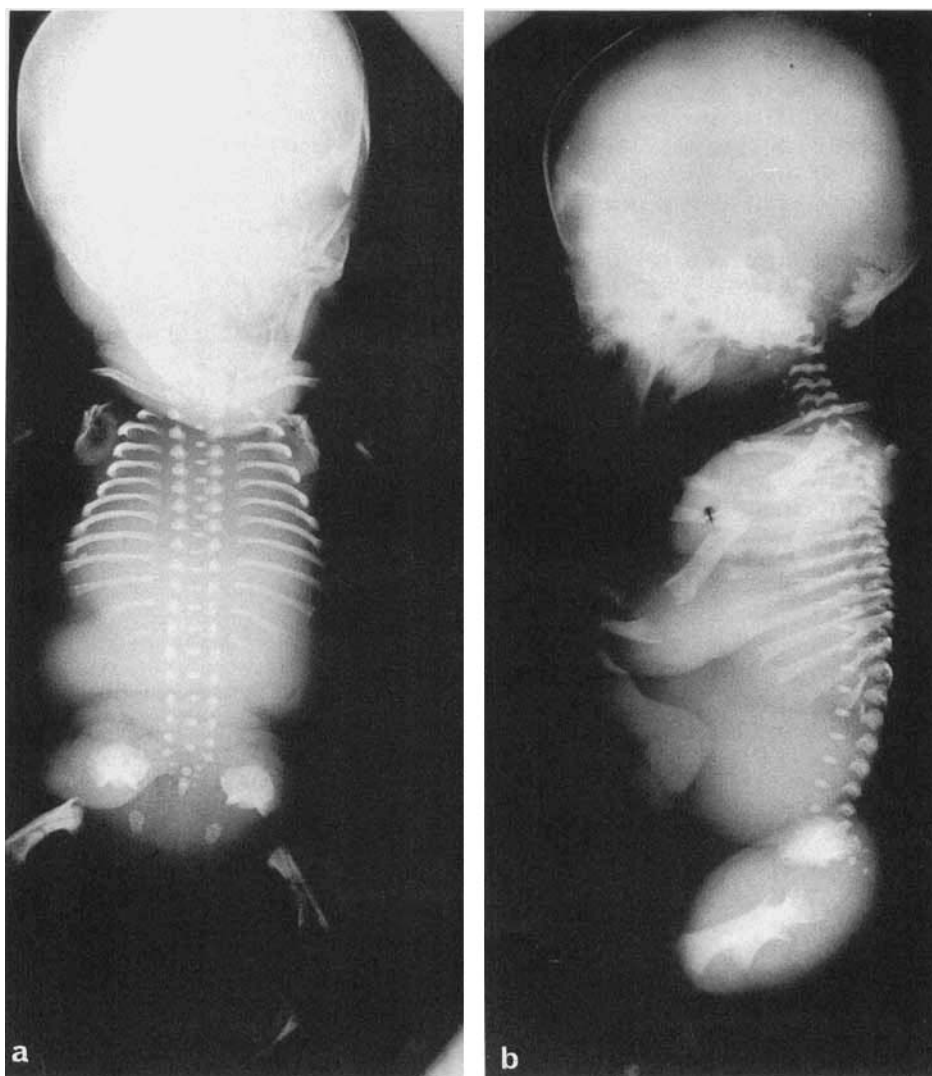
Radiographs of patient 1 at 24 weeks of gestation. Note wafer-thin vertebral bodies (a,b), and short and broad iliac bones with a concave inferior margin and a trident shape (a). The tubular bones are short and broad with ragged metaphyseal borders. b: The ribs are short and their lateral ends are splayed.
